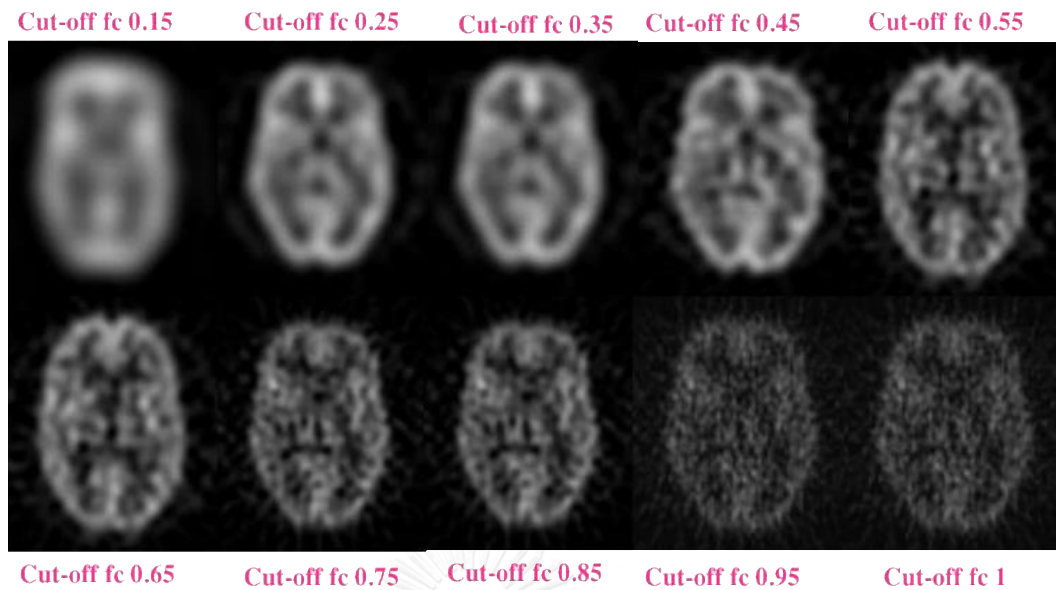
Figure B 2. The brain SPECT images by varying cut-off frequencies in low activity concentration (FBP method)
